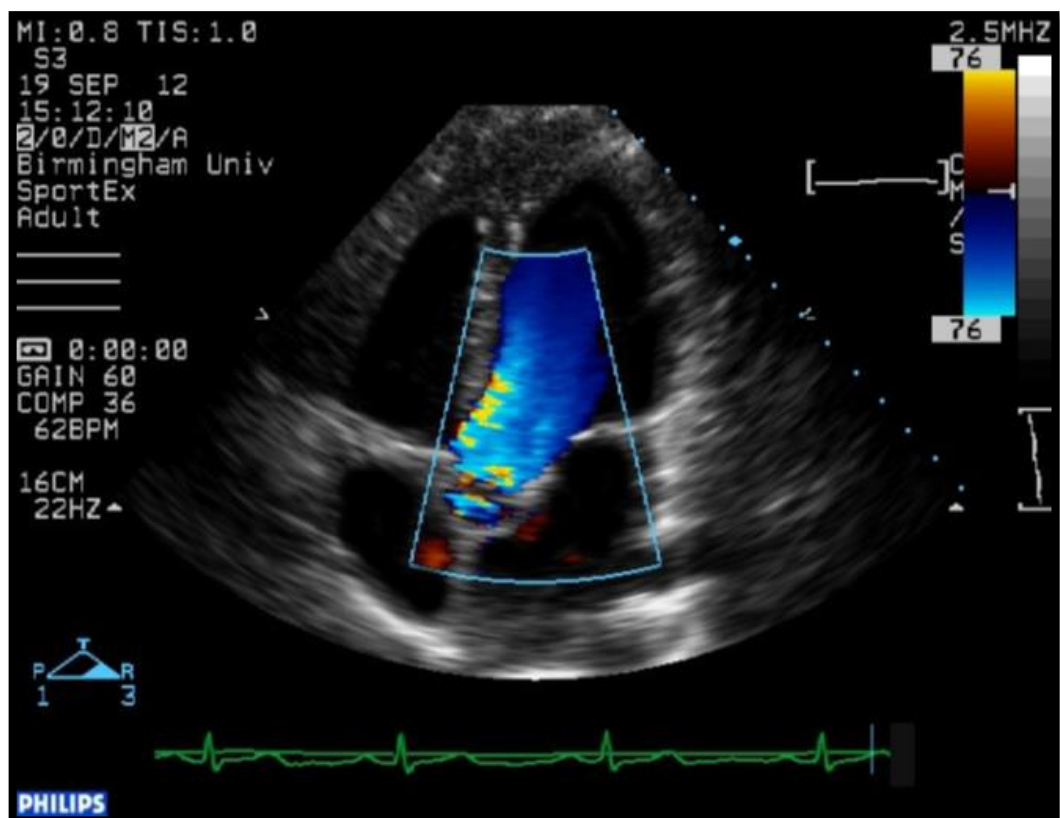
The flow of blood exiting the heart through the aortic valve during systole, visualised in colour Doppler mode from an apical 5-chamber view
